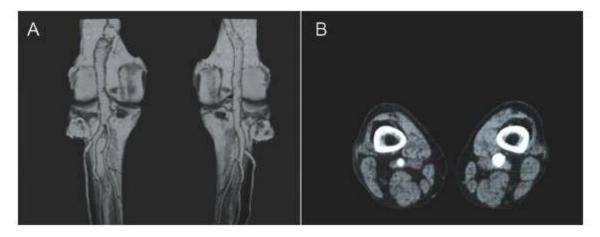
A) Three-dimensional reconstruction (Angio-CT); B) axial section (Angio-CT)
